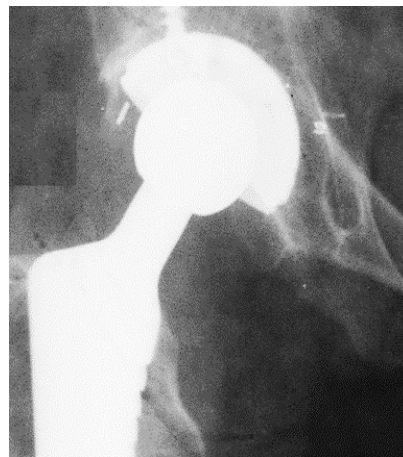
Right hip X-ray showing the absence of heterotopic ossification.*
